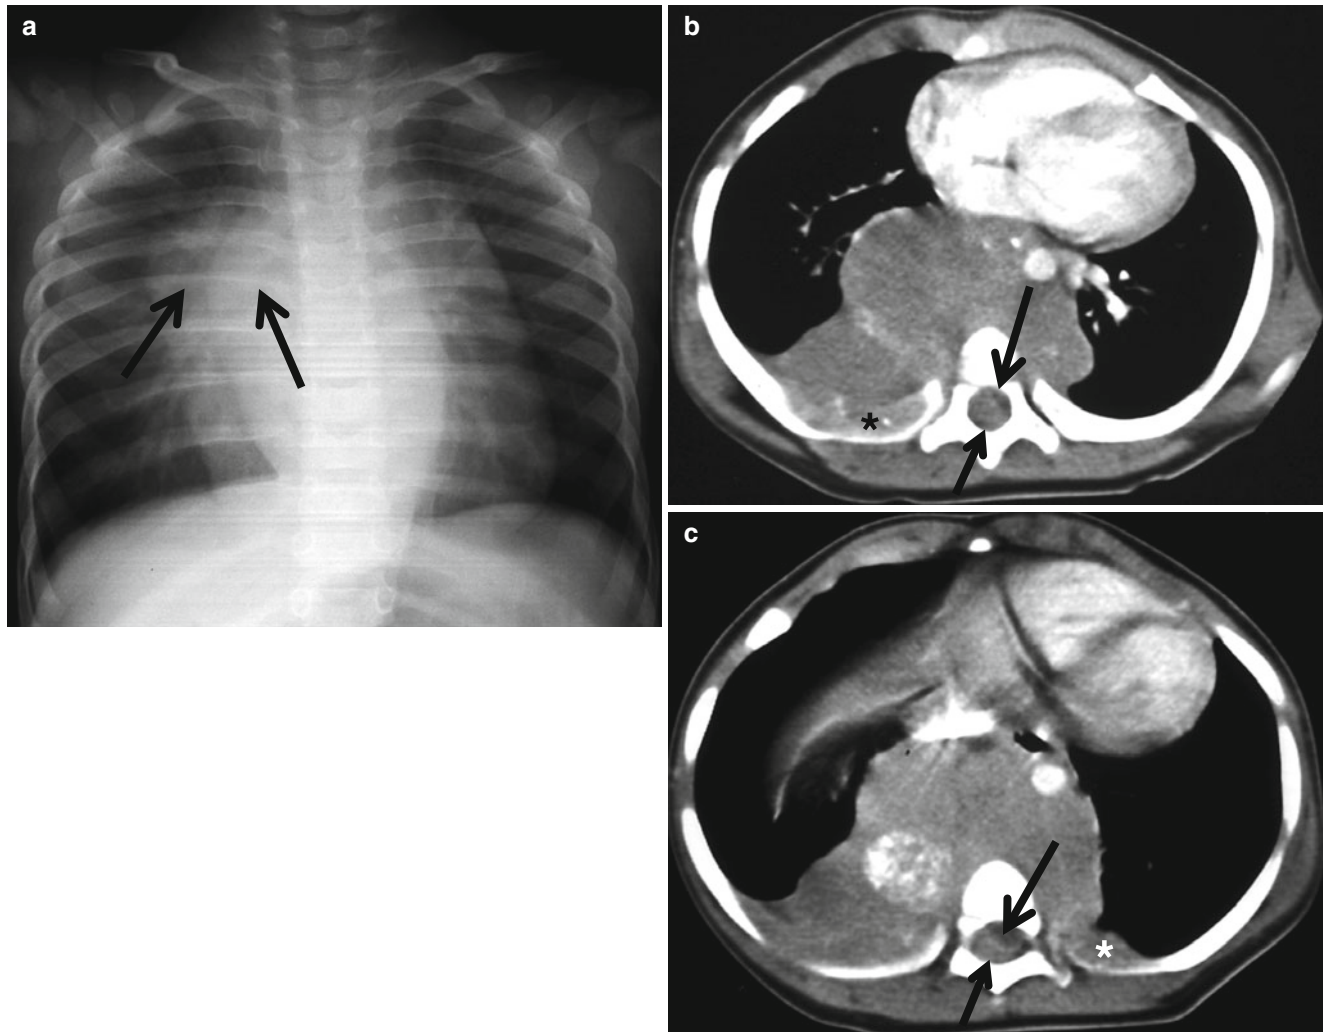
Primary mediastinal neuroblastoma with intraspinal extension in a 12-month-old girl with irritability. (a) Plain radiograph shows bilateral paraspinal and posterior mediastinal masses with posterior rib erosion (*arrows*). (b, c) Contrast-enhanced CT shows a large soft tissue
